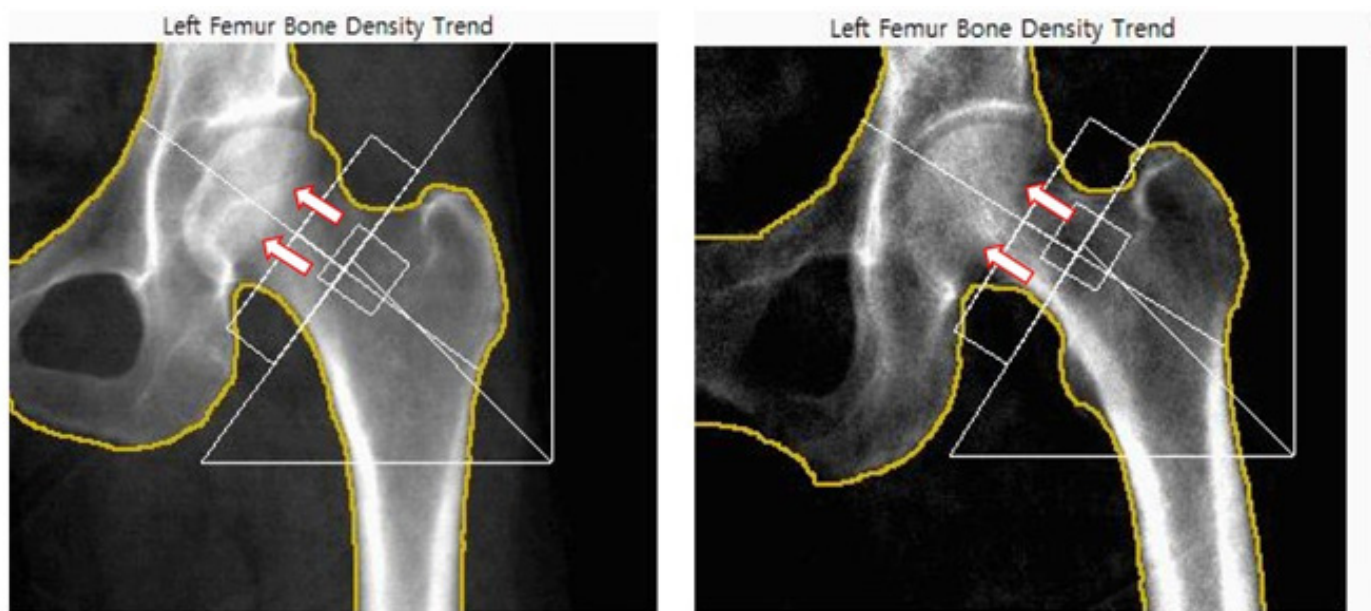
Comparison of left proximal femur BMD images. The bone mineral densitometry (BMD) image using dual-energy X-ray absorptiometry (DXA) obtained from a 55-year-old female participant referred from a clinical trial center demonstrates decreased acetabular coverage (arrows), relative acetabular shallowness, increased superolateral exposure of the femoral head, and mild degenerative changes, raising suspicion of mild acetabular dysplasia (A). Additional review by a nuclear medicine physician supported these findings. In contrast, the BMD image of a normal subject demonstrates adequate acetabular coverage (arrows) and normal containment of the femoral head (B).
